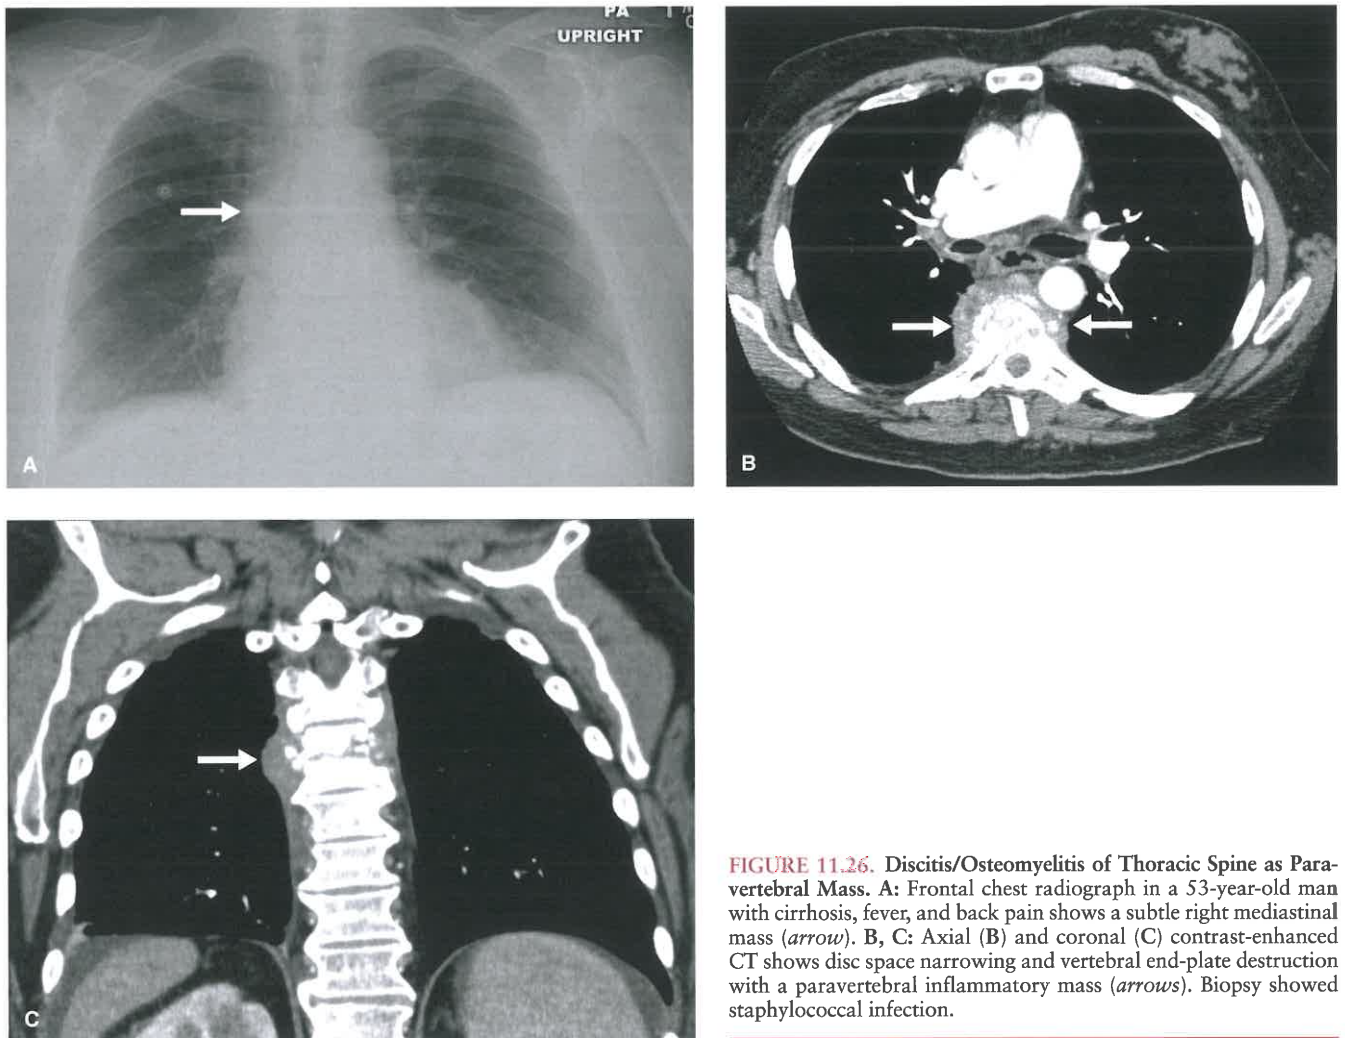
Discitis/Osteomyelitis of Thoracic Spine as Paravertebral Mass. A: Frontal chest radiograph in a 53-year-old man with cirrhosis, fever, and back pain shows a subtle right mediastinal mass (*arrow*). B, C: Axial (B) and coronal (C) contrast-enhanced CT shows disc space narrowing and vertebral end-plate destruction with a paravertebral inflammatory mass (*arrows*). Biopsy showed staphylococcal infection.
